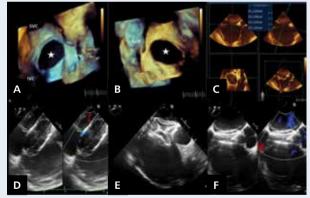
Transoesophageal echocardiogram; A, B. Threedimensional images of the atrial septal defect (white star) viewed from the right (A) and left (B) atrial perspectives; C. Multiplanar reconstruction of the atrial septum with measurements of the defect; D. Over-inflation of the sizing balloon in an attempt to reach stop-flow; E. Both discs of the occluder deployed but held splayed by the inflated (dashed white line) sizing balloon; F. Final result after release of the device; SVC — superior vena cava; IVC — inferior vena cava; TrV — tricuspid valve; AoV — aortic valve
